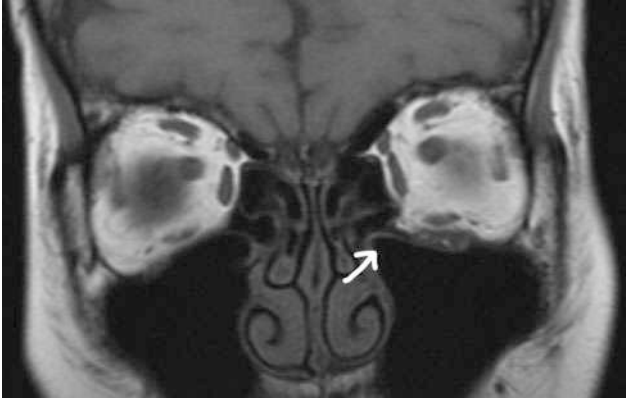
Coronal MRI demonstrating inferior displacement of the inferior rectus in an orbital floor fracture
